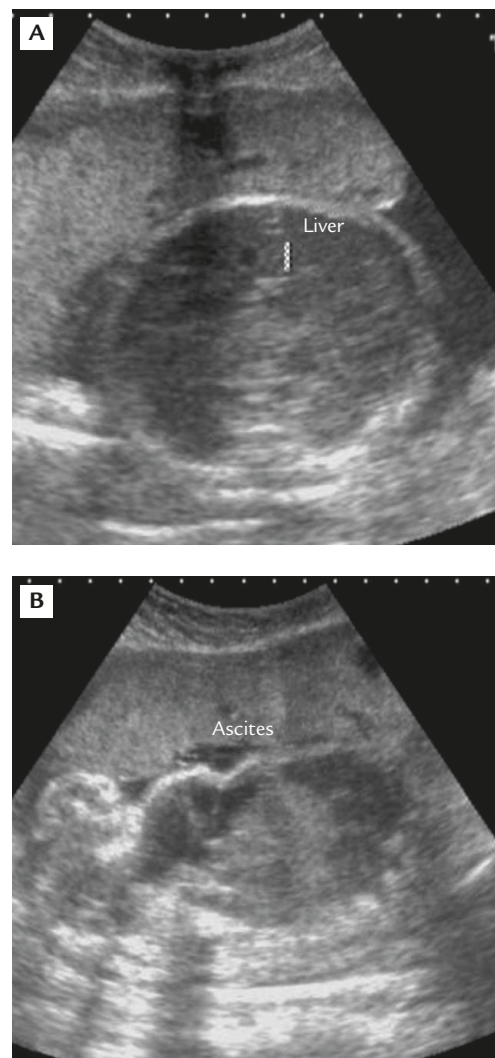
Prenatal ultrasound at 32 weeks' gestation shows: (A) hepatosplenomegaly, and (B) fetal ascites.
